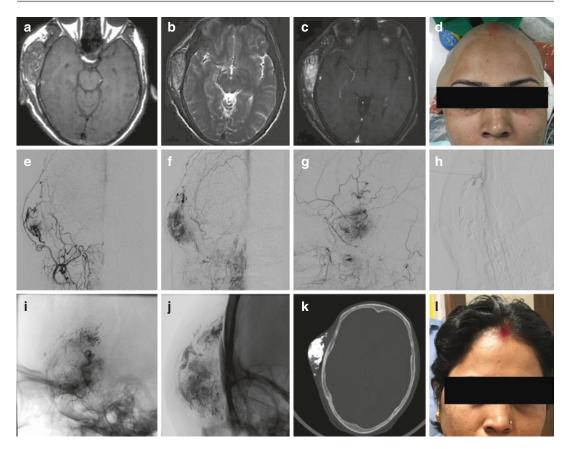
Thirty-two-year-old lady with right temporal scalp swelling since childhood. (a, b & c) MRI T1WI, T2WI, Post-contrast T1WI showing soft tissue lesion in the right temporal scalp region which is intensely enhancing on post-contrast study. (d) Clinical picture before embolization. (e & f) Right ECA angiogram in early arterial and late arterial phase shows intense vascular blush. (g) Late arterial phase in lateral view. (h) Direct puncture of the lesion done with 24G scalp vein needle. Check
